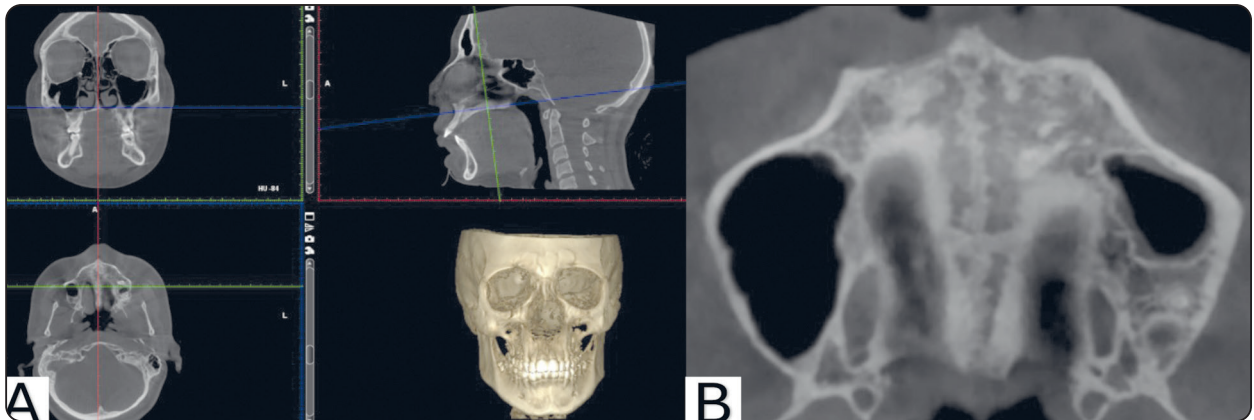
CBCT images showing the adjustment of the scan for the midpalatal suture assessment: (A) Adjustment of the position indicator of the image which is positioned at the patient’s midsagittal plane in both the coronal and axial views (red lines) and parallel to the antero-posterior long axis of the palate in sagittal image (blue line). (B) A central axial CBCT image showing MPS maturation stage (C) where the suture presents as two lines that are radiopaque, scalloped, parallel and separated by areas of low radiographic density according to Angelieri et al., 2013.⁽¹²⁾
